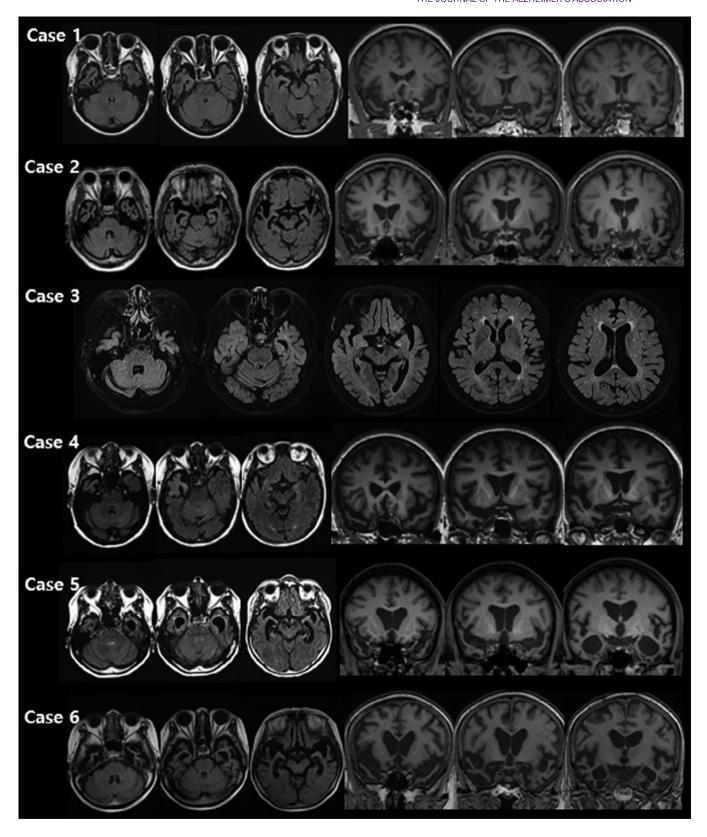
Brain MRI images of cases with D40G of ANXA11. FLAIR axial and T1-weighted coronal brain MR images of each patient showed bilateral anterior temporal atrophy (case 5), worse on the right (case 1, 2, 4, 6) or left (case 3). FLAIR, Fluid-attenuated inversion recovery; MRI, magnetic resonance imaging.
